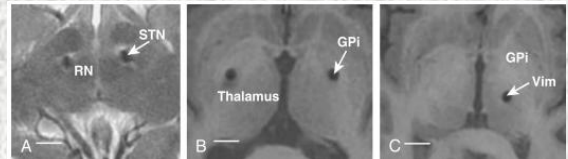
A to C, Magnetic resonance images of deep brain stimulation electrodes (arrows). There are implanted in three preferred zones: (A) the subthalamic nucleus (STN), (B) globus pallidus (GPi) and (C) ventral intermediate nucleus of the thalamus (Vim). (RN, red nucleus). Scale bars = 10 mm <sup>4</sup>.
